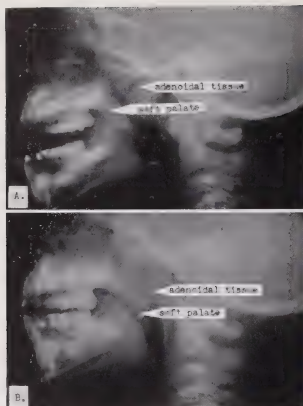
Lateral soft tissue roentgenograms showing narrowing of the nasopharyngeal space by adenoidal tissue (Case 2). A, Enlarged adenoids during inspiration. B, Enlarged adenoids with respiration suspended prior to third operation. Note complete occlusion of nasopharyngeal airway.
